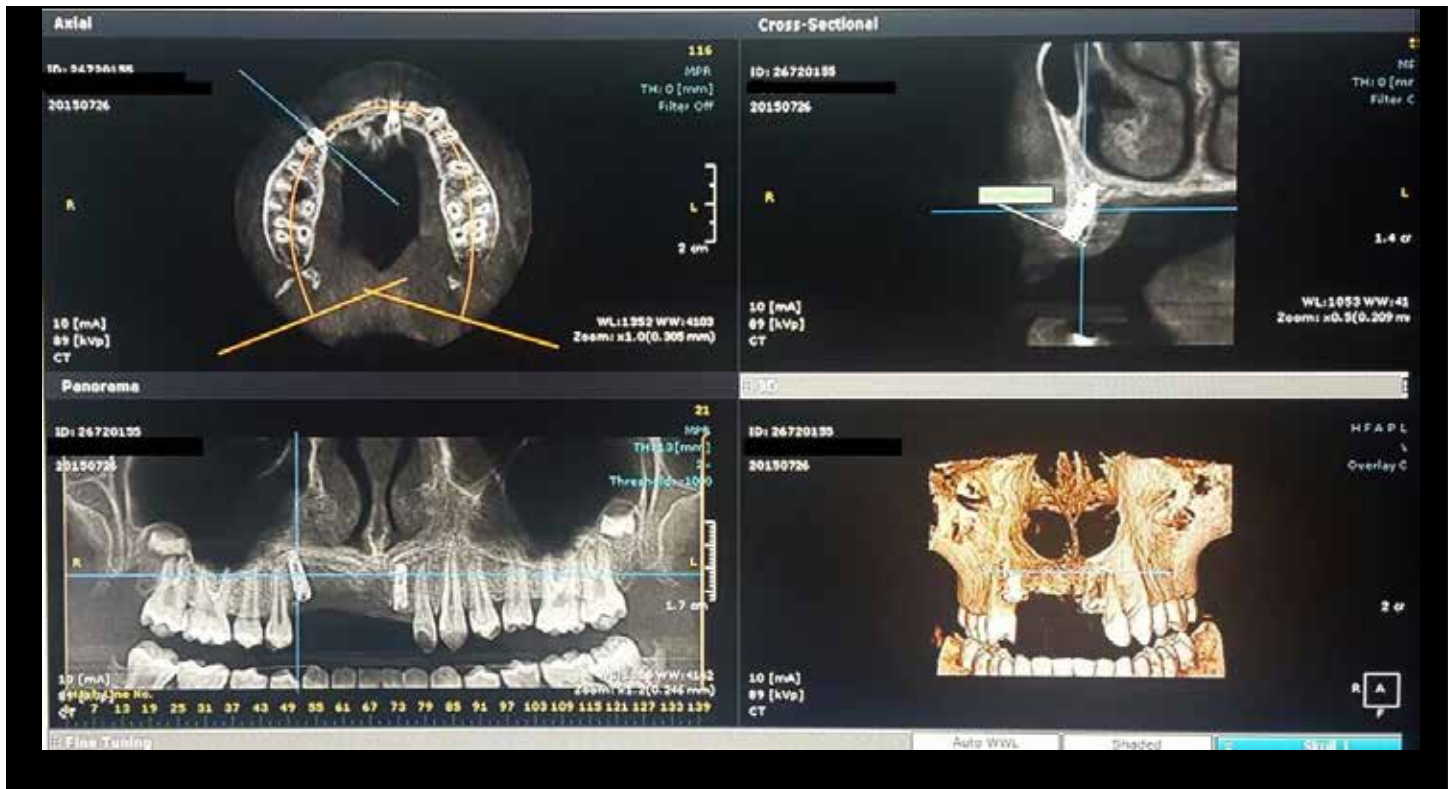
Six months postoperative CBCT showing the increase in ridge width measurements and the implant in place.
